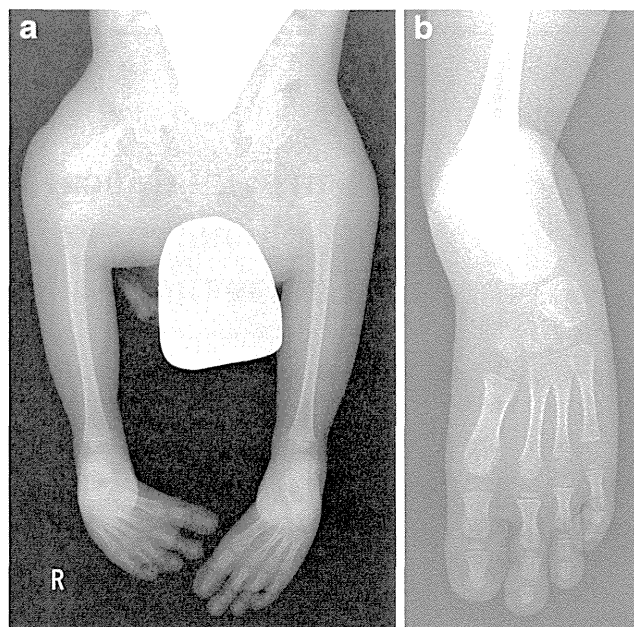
Anteroposterior radiographs at the age of 3.5 years. a The pelvis and lower limbs demonstrate small and narrow ilia, malformed ischiopubic bones, deficient acetabula, complete absence of the left femur, rudimentary right femur, absent fibulae and slender tibiae with ball-shaped large epiphysis of the left tibia. b The left foot demonstrates four pairs of metatarsals and phalanges without deformity of tarsal bones
